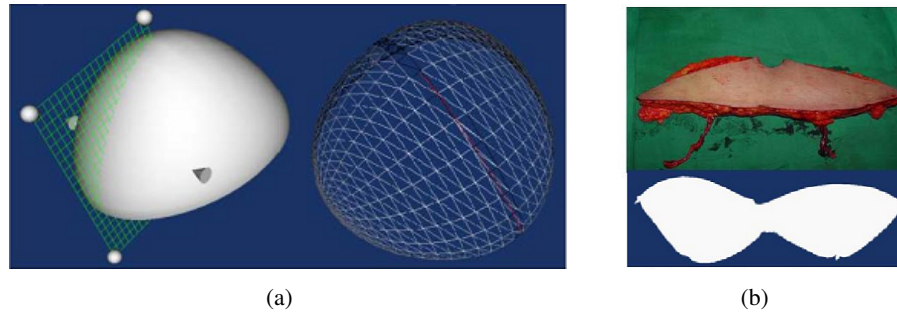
The method proposed by Haung *et al.*; (a) the triangulated mesh resulted from processing MRI acquisition, and (b) the real flap used for breast reconstruction vs the virtual calculated one; images are adopted from [87]).
